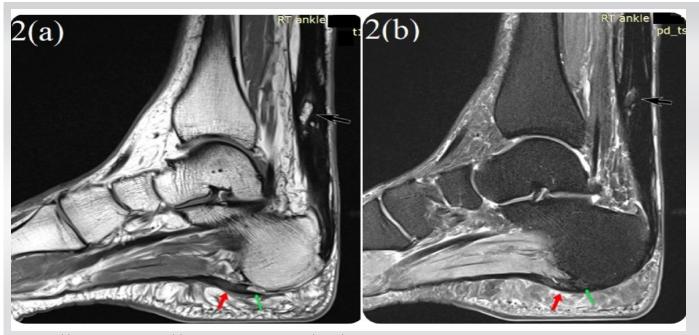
(a) Sagittal T1 weighted, (b) proton density fat saturated (PDFS) magnetic resonance images of the ankle reveal a prominent plantar calcaneal enthesophyte (green arrows), and thickened plantar fascia measuring about approximately 5 mm adjacent to the calcaneal spur (red arrow), showing hyperintensity on the PDFS image. Significant heel fat pad edema and a partial tear of the Achilles tendon approximately 5 cm proximal to the insertion with multiple intra-tendinous osseous bodies (black arrow) is also evident in the image.
